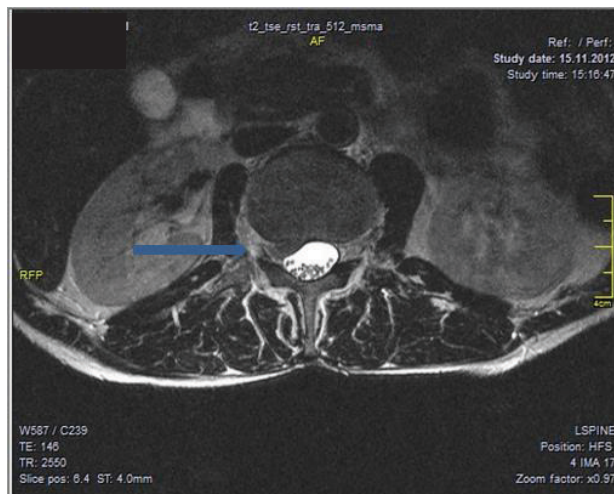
MRI Axial T2: Right lateral reces ruptured L2-L3 LDH, piercing PLL (blue arrow). The patient was operated (fenestration L2-L3, resection of ruptured right L2-LDH, bilateral stabilisation L3-L4-L5 with titan screws and postero-lateral bone graft L4 harvested from iliac crest.).
